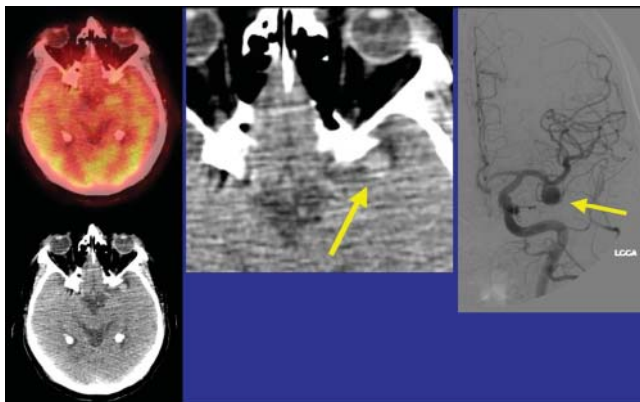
One example of life-threatening incidental findings identified on PET/CT studies were these images of an unsuspected 12-mm middle cerebral artery aneurysm.
